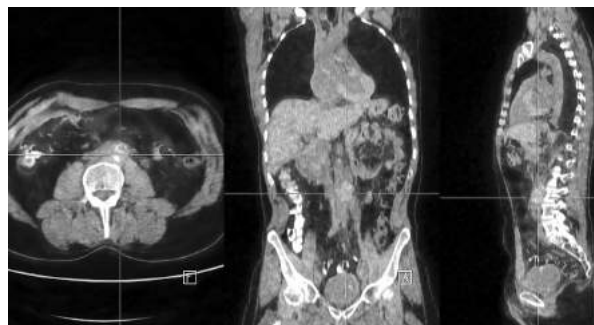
A 36-year-old man with stage IV disease from left-sided nonseminoma (embryonal cell carcinoma). Initial treatment: right orchiectomy + chemotherapy + RPLND. Referred to PET for evaluation of CT abnormality. ^{18}F -FDG PET-CT scan revealed FDG-avid left paraaortic lymph node (SUV max 5.5). He was operated (RPLND), PH: Necrosis.
